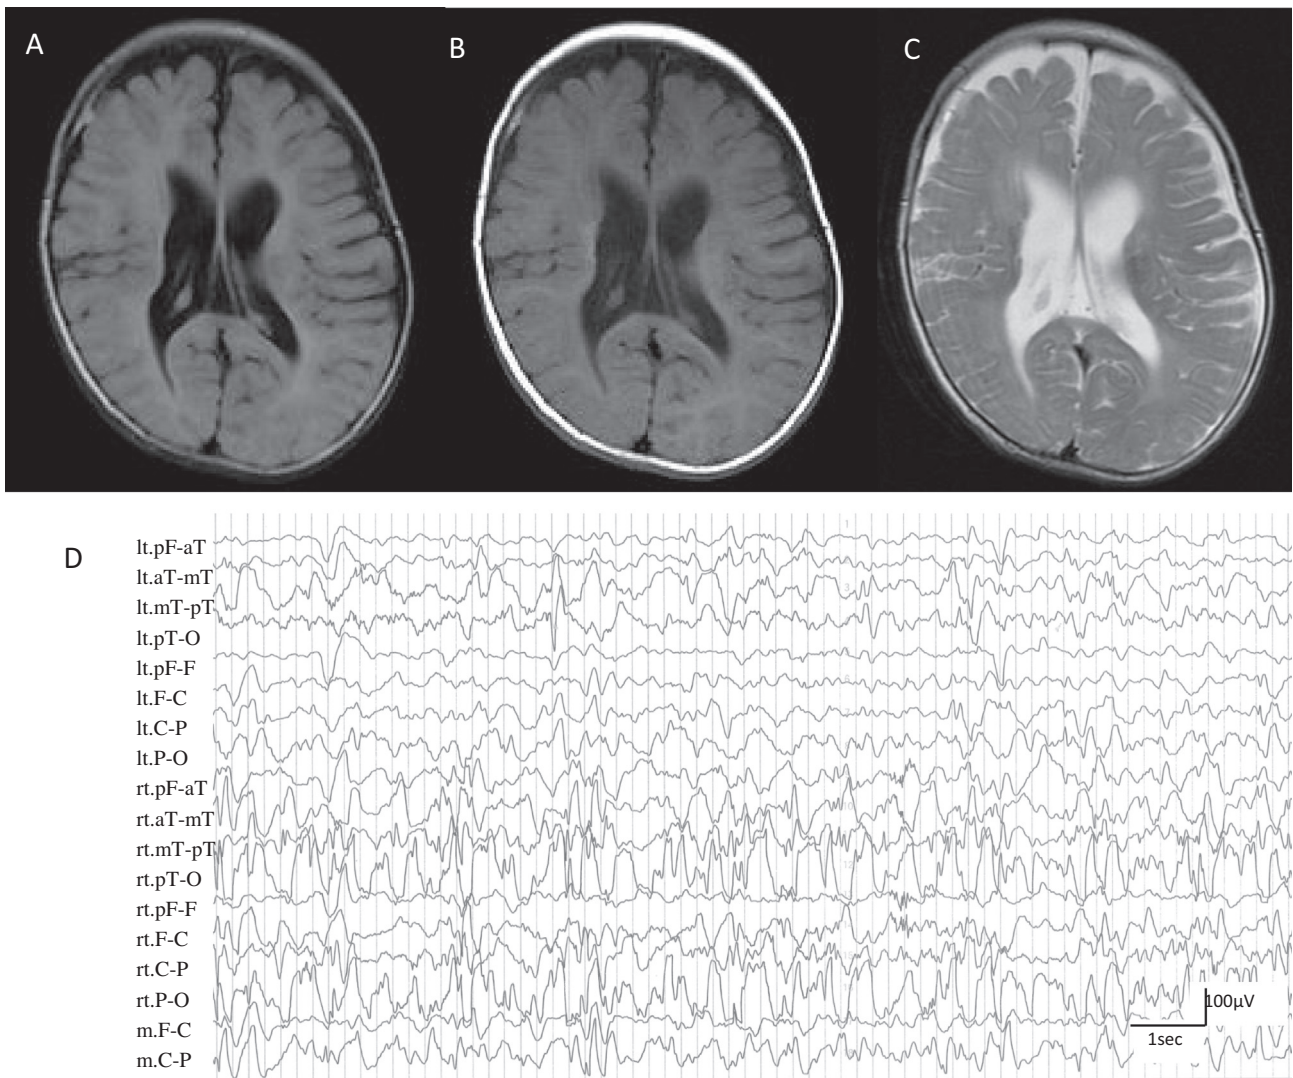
Magnetic resonance imaging (MRI) and electroencephalogram (EEG) at 6 months of age. MRI (A: T1WI, B: fluid-attenuated inversion recovery [FLAIR], C: T2WI) shows a high signal intensity area in the right lateral ventricular wall on T1-weighted and FLAIR images, and decreased signal intensity on a T2-weighted image. Inter-ictal EEG shows almost continuous irregular high voltage spikes-and-waves in right posterior quadrants, which was considered hemihypsarrhythmia (D).
